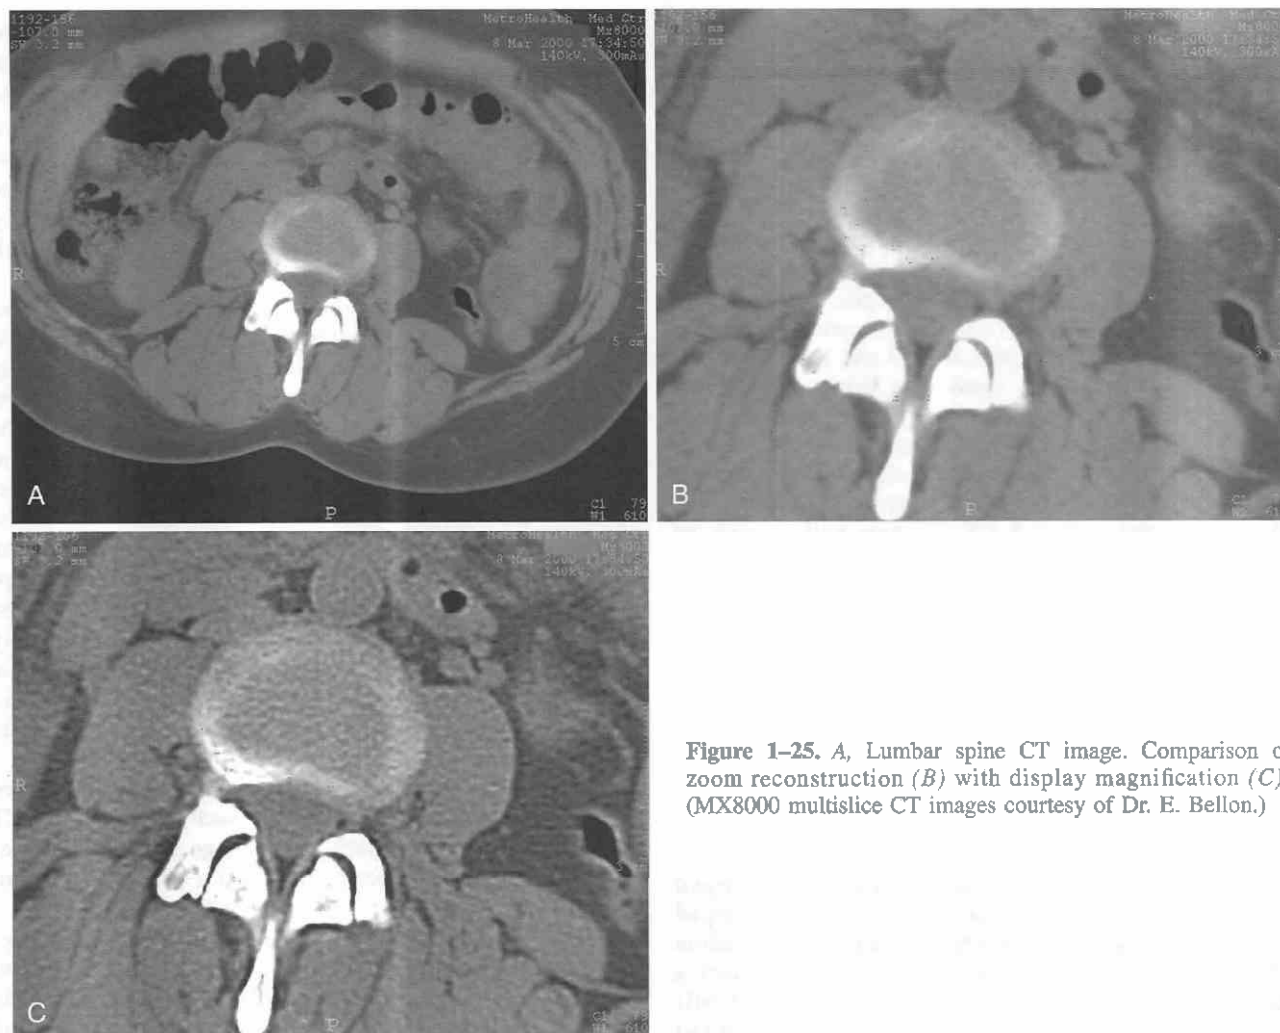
A, Lumbar spine CT image. Comparison of zoom reconstruction (B) with display magnification (C). (MX8000 multislice CT images courtesy of Dr. E. Bellon.)
